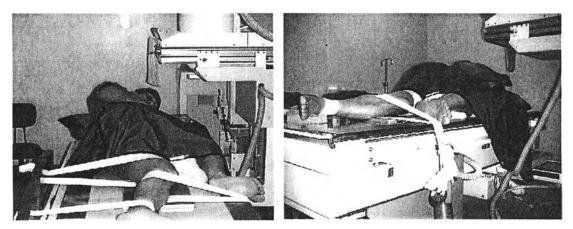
Technique of a simplified stress radiography in diagnosis of a torn ACL
